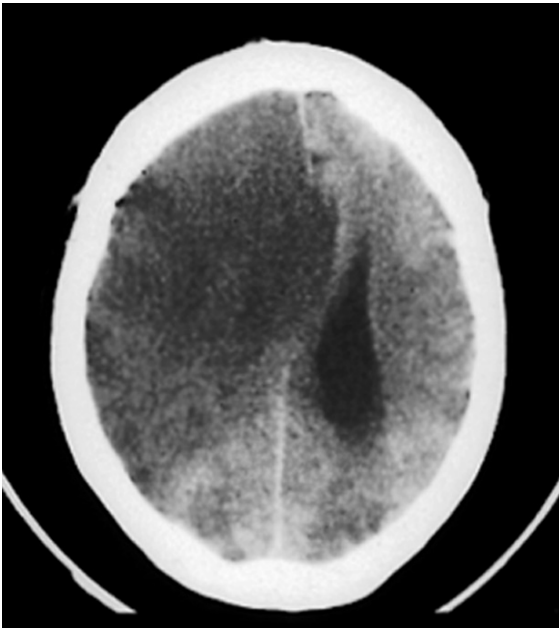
Hemispheric cerebral infarction. Unenhanced axial CT demonstrates a large hypodense area in the vascular distribution of the right anterior and middle cerebral arteries associated with mass effect.
